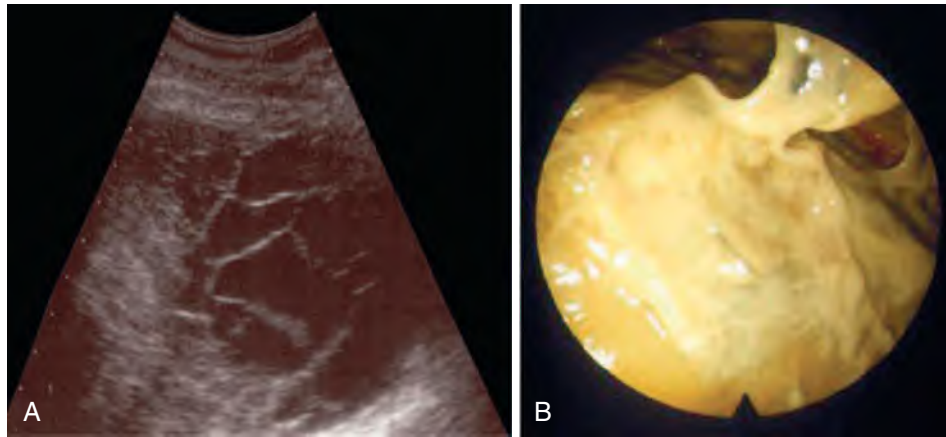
Multiloculated pleural empyema. (A) Ultrasonographic image of a multiloculated pleural empyema and (B) extensive fibrin deposition with septation and pockets of pus as seen during a medical thoracoscopy in a patient with multiloculated pleural empyema (category 7 according to Light¹¹). Such septae prevent a successful evacuation of pus by simple chest tube drainage. (From Brutsche MH, Tassi GF, Gyorik S, et al. Treatment of sonographically stratified multiloculated thoracic empyema by medical thoracoscopy. *Chest*. 2005;128:3303–3309.)
